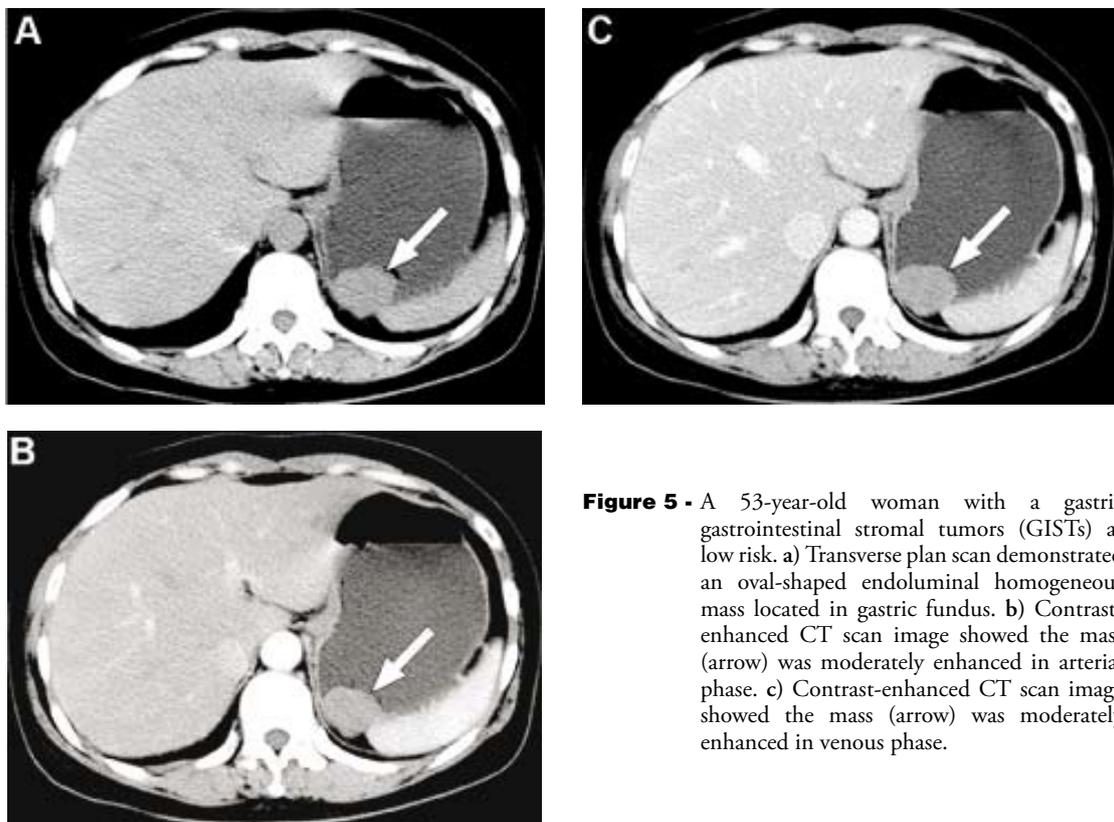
A 53-year-old woman with a gastric gastrointestinal stromal tumors (GISTs) at low risk. a) Transverse plan scan demonstrated an oval-shaped endoluminal homogeneous mass located in gastric fundus. b) Contrast-enhanced CT scan image showed the mass (arrow) was moderately enhanced in arterial phase. c) Contrast-enhanced CT scan image showed the mass (arrow) was moderately enhanced in venous phase.
